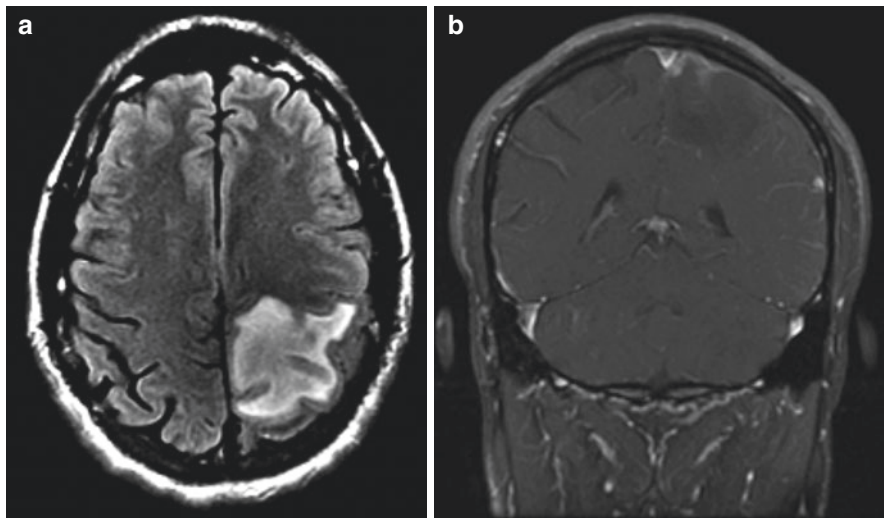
Magnetic resonance image (MRI) showing an intracranial gumma. (a) Axial fluid attenuated inversion recovery (FLAIR) image showing vasogenic edema in the left fronto-parietal region. (b) Coronal post-contrast T1-weighted image showing the gumma as an enhancing dural-based mass with surrounding edema and mild mass effect. (Courtesy of the author, Dr. Marra)
